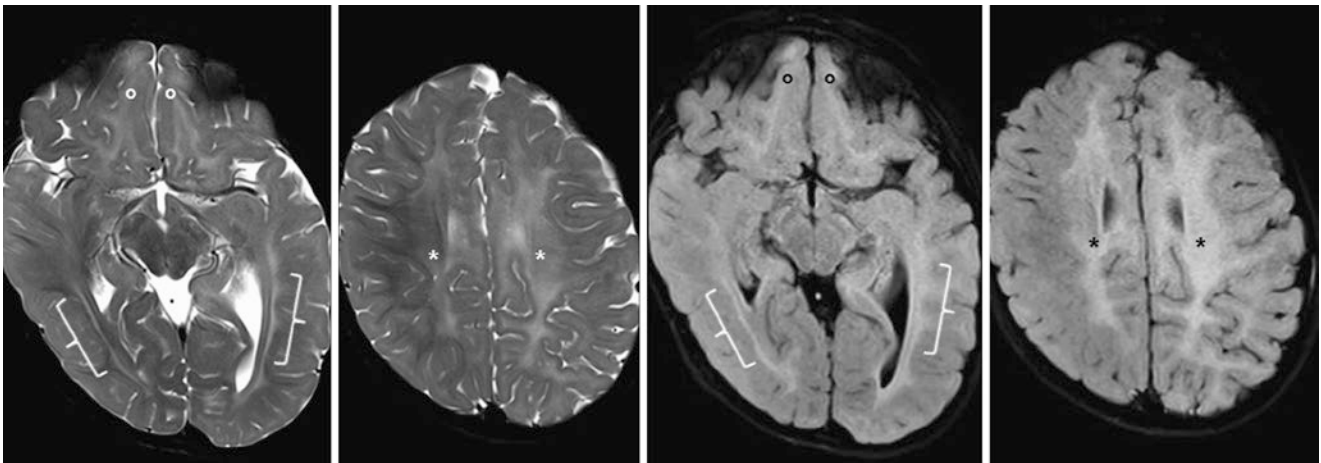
Comparison case of velocardiofacial syndrome (VCFS, 22q11.2 deletion syndrome). A 23-month-old had a 3T MRI that showed hyperintense signal within the optic radiations (brackets), OFWM (circles), and supraventricular WM (asterisks) on FLAIR (left
